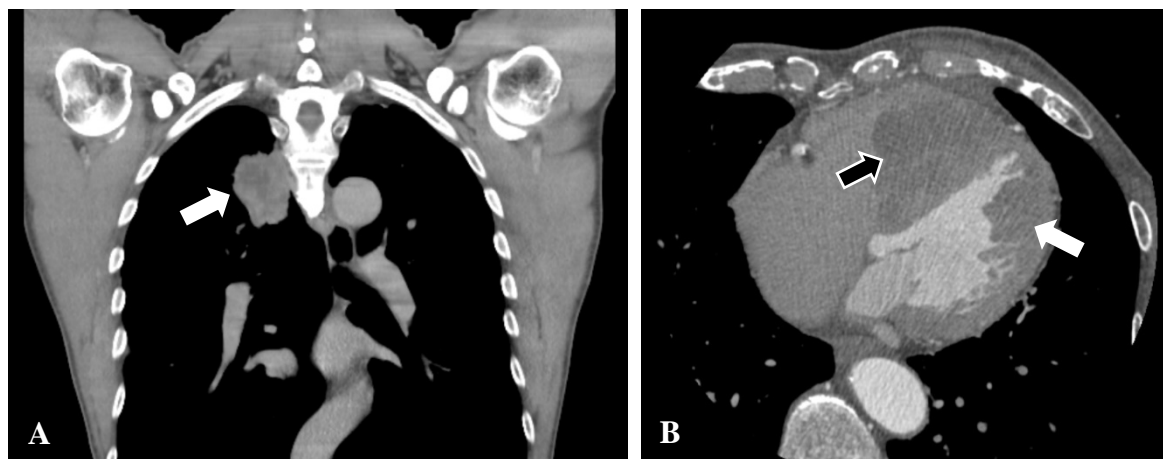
Chest computed tomography (CT) shows lobulated mass (white arrow) at posterior segment of the right upper lung. (A) Computed tomography pulmonary angiography (CTPA) demonstrates masses at the right ventricle (black arrow) and left ventricle (white arrow). (B)
